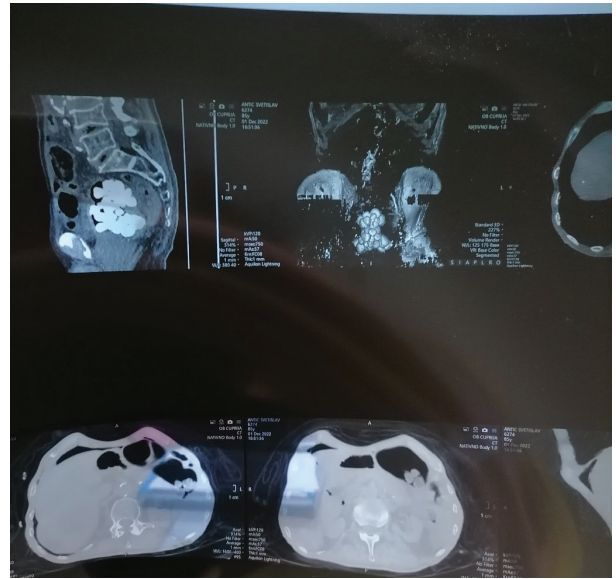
Initial preoperative abdominopelvic CT shows multiple bladder stones
